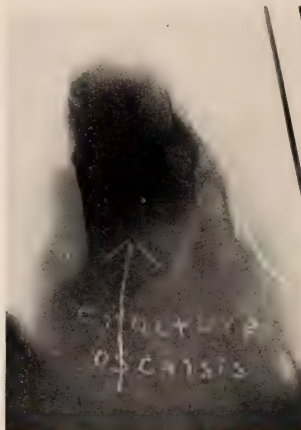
Radiograph of os calcis, showing fracture, Watter's position.
